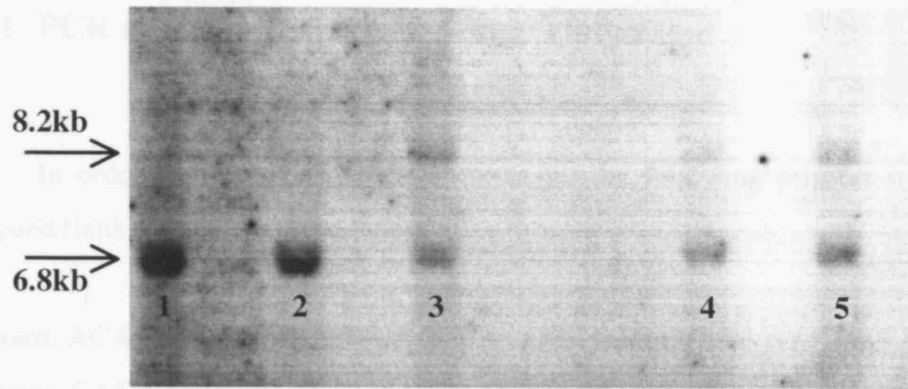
X-ray film (48 hour exposure) of the ^{32}P labelled probe hybridised to *Xcm* I digested ES cell DNA. Lane 1 is a *Fhl*^{+/+} control and lanes 2-5 are the four ES clones subject to screening. Lane 2 is clearly *Fhl*^{+/+} as only a 6.8kb band is visible whereas lanes 3,4 and 5 have both a *Fhl*^{+/+} and a *Fhl*^{fl/+} (8.2kb). This indicates that 1 copy of endogenous *Fhl* has been successfully targeted with pFLRT-loxP-FH-loxP.
